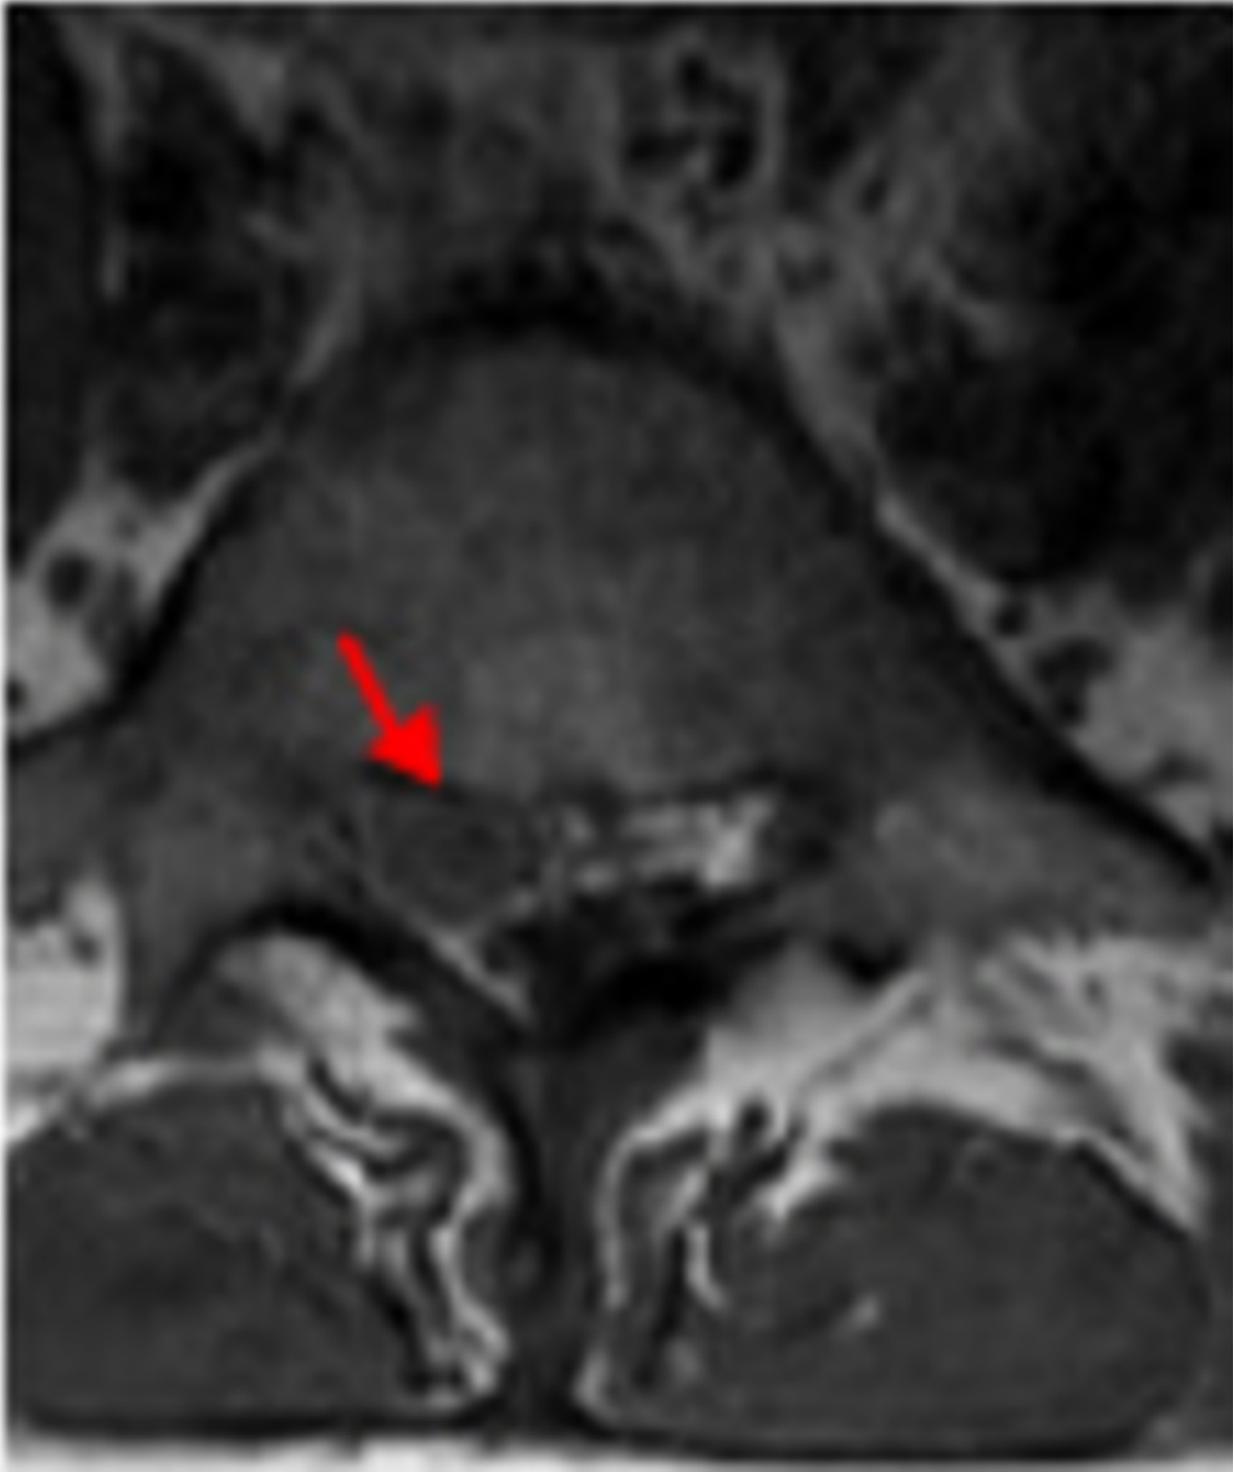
Axial T2 Weighted Lumbar Spine MRI image showing Right Subarticular Disc Herniation
